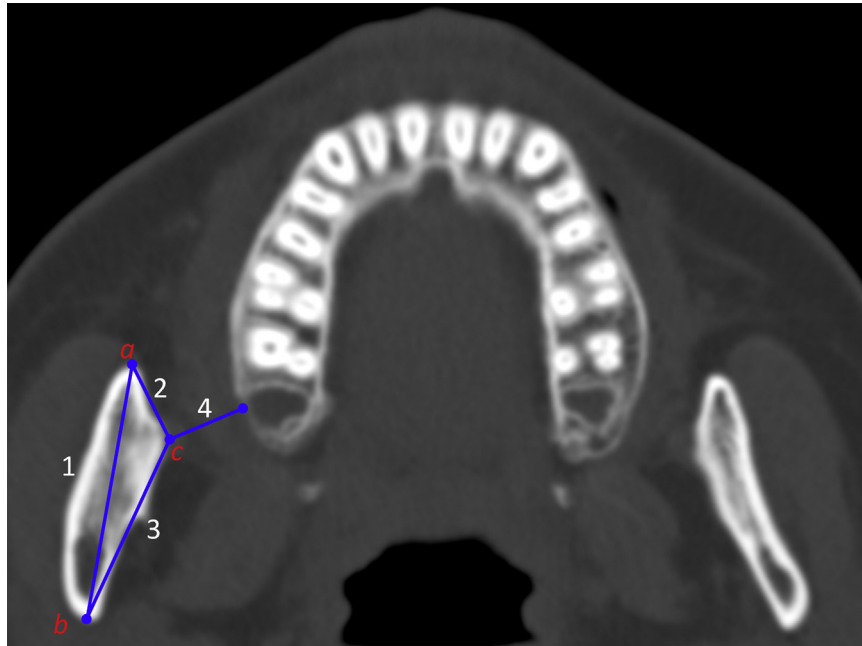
Reference points and regions on CT images.
